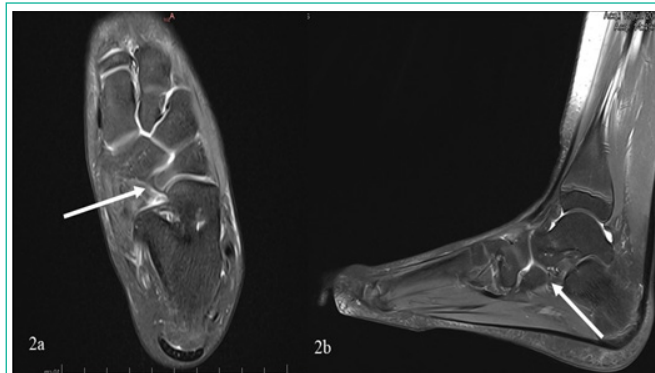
The MRI of the left foot confirmed the presence of an extended medial cuboid process that insinuated itself between the anterior process of the calcaneus and the navicular (arrow on the figure 2a), and which articulated with the talus plantar face (arrow on the figure 2b).
